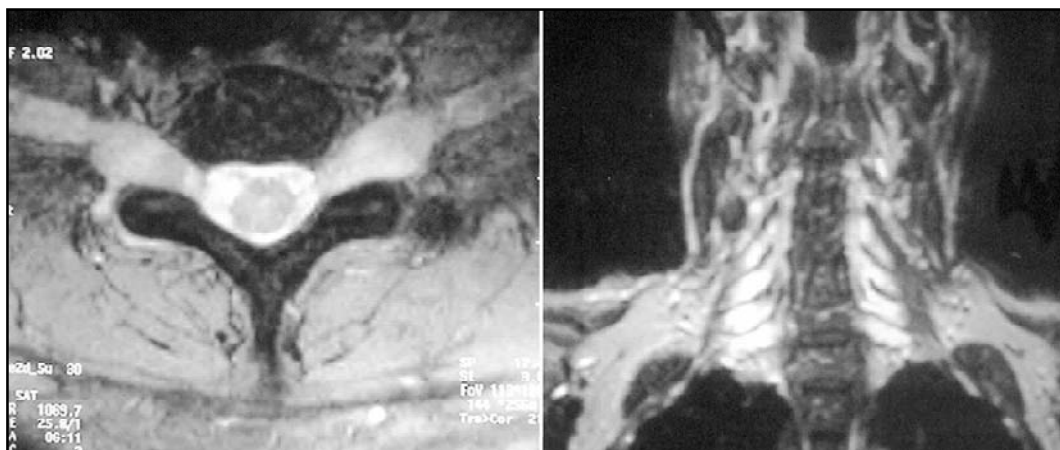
Case 1. Axial and coronal T2 weighted cervical spinal MRI showing roots hypertrophy.
